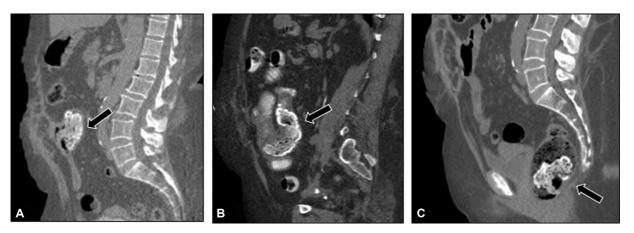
Sequential sagittal computed tomography scans on day of presentation (A), 7-month (B) and 8-month (C) show progressive migration of the mesh from jejunum to the rectum (black arrow).
